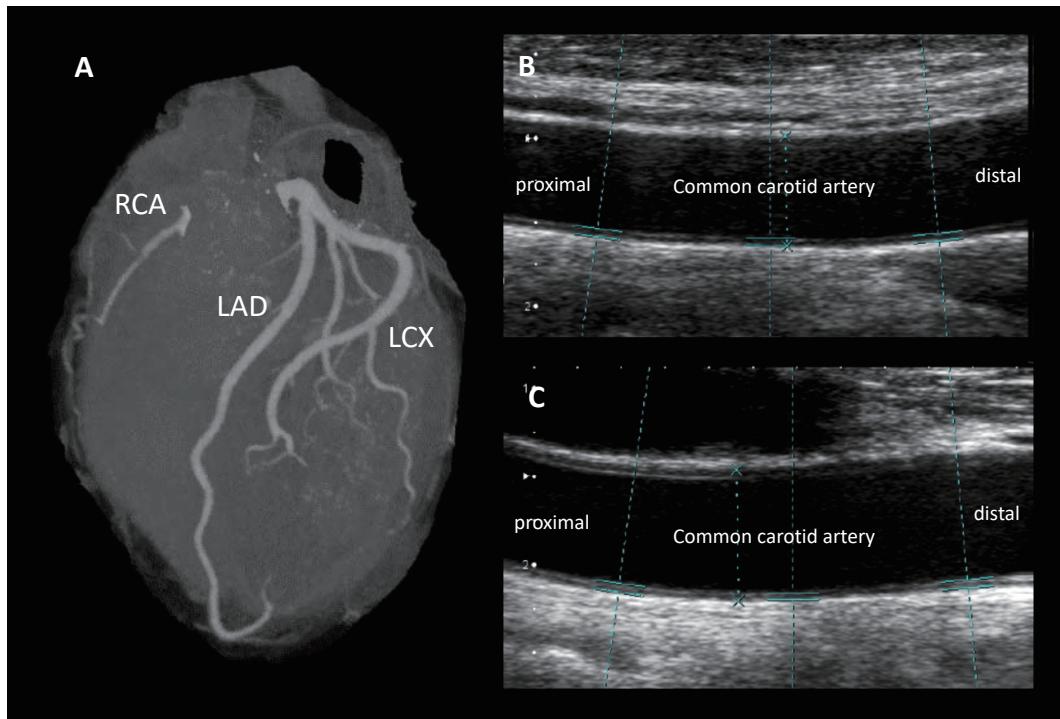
Images of coronary computed tomography and carotid ultrasound in a patient with ABL
